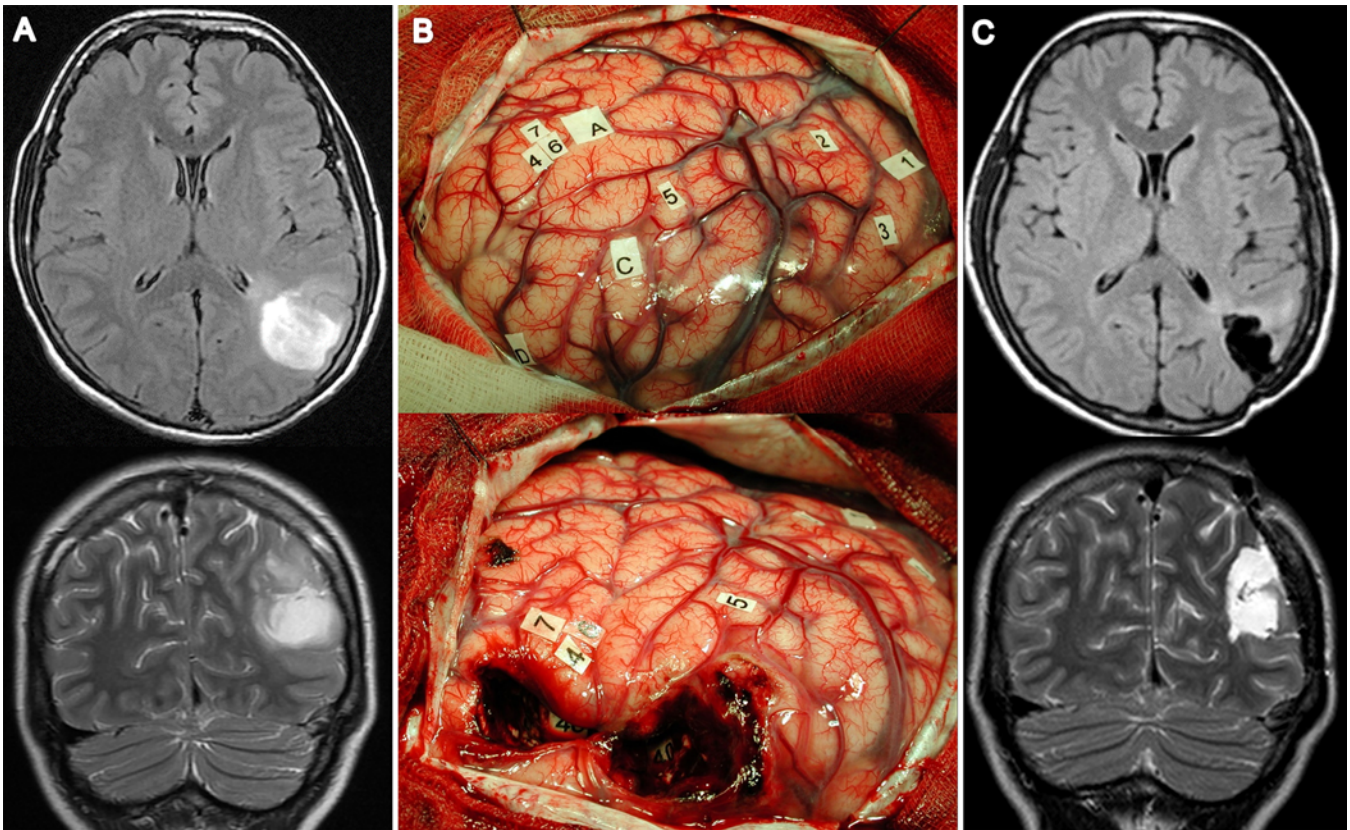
Case 1. Awake resection of a WHO grade 3 oligodendroglioma involving the left parietotemporal junction in a piano teacher. A: Preoperative axial FLAIR (*upper*) and coronal T2-weighted (*lower*) MR images showing a left glioma. B: Intraoperative photographs obtained before (*upper*) and after (*lower*) connectome-based resection. C: Postoperative axial FLAIR (*upper*) and coronal T2-weighted (*lower*) MR images showing a subtotal resection.
